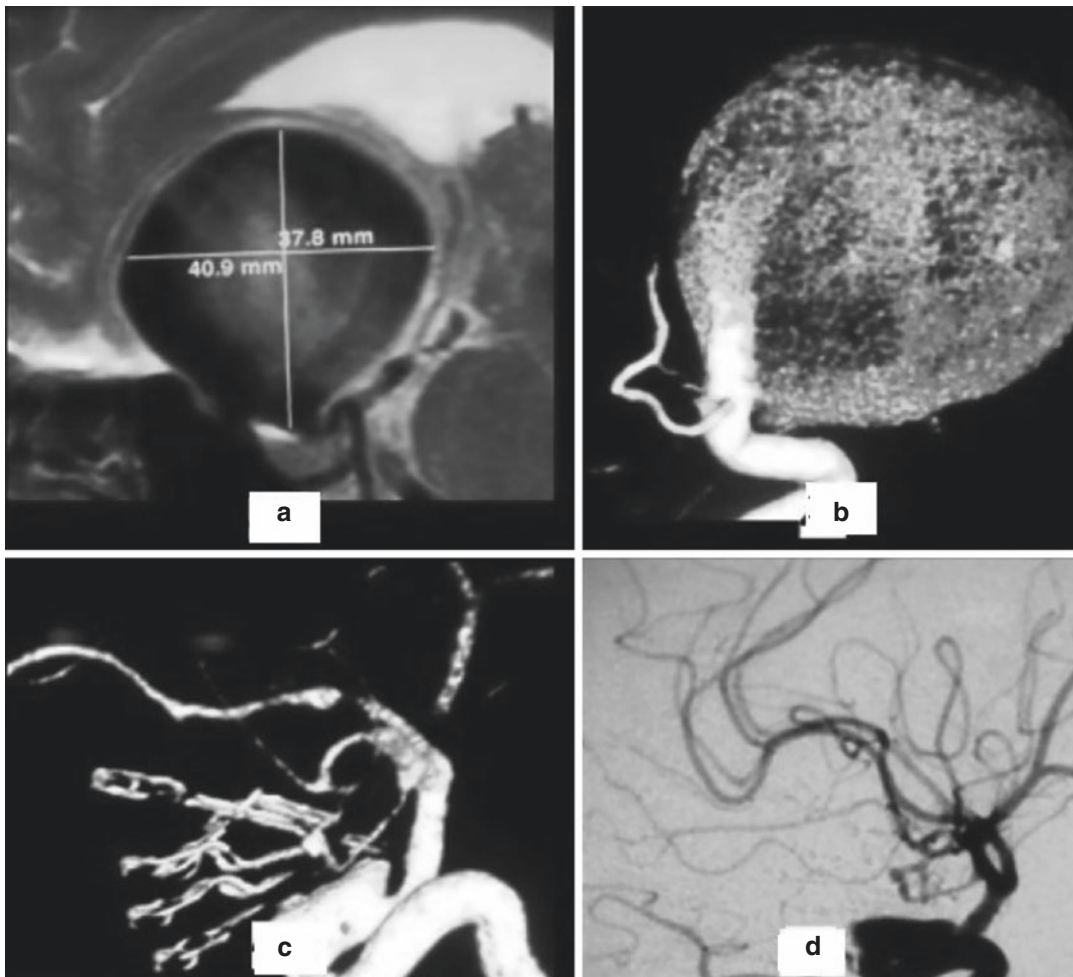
(a) shows MRI brain with a giant left carotid-ophthalmic segment aneurysm. (b) Shows 3D reconstructed image of DSA. (c, d) Shows postoperative CTA and DSA respectively with obliteration of the aneurysm
